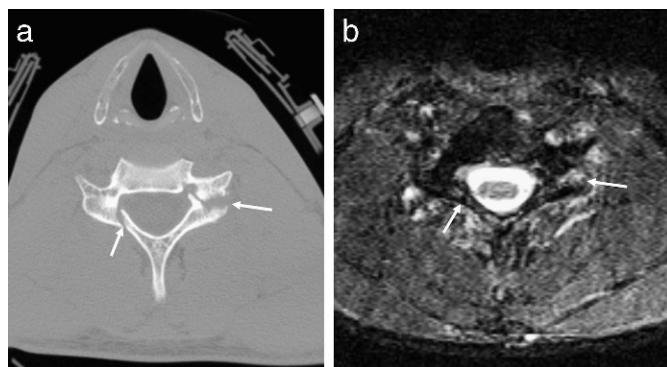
Bony detail with CT. (a) Axial CT demonstrates fractures of the posterior elements of C5 (arrows). (b) Axial STIR sequence at the same level does not show the fractures as clearly, although soft-tissue and intraosseous edema is present (arrows).
